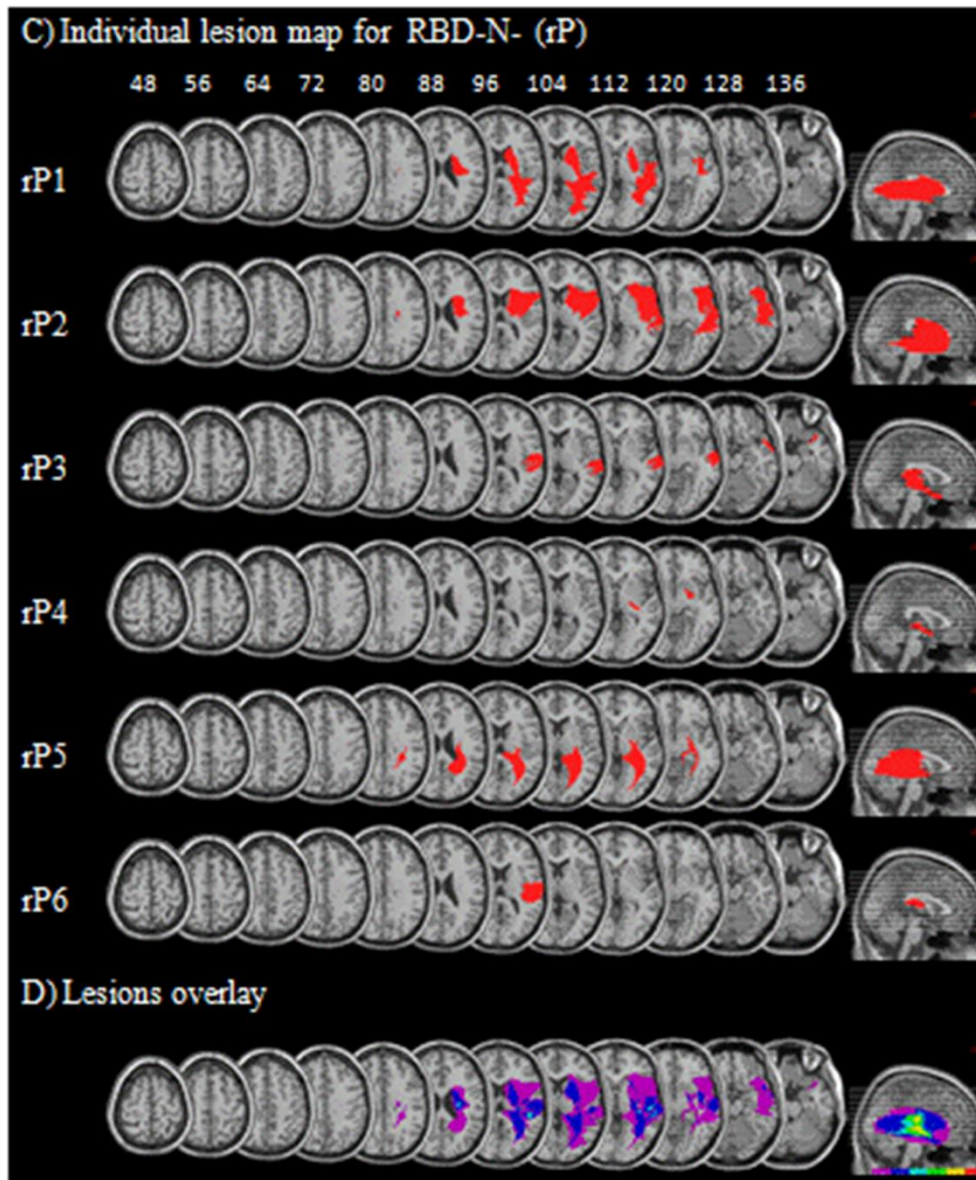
CT/MRI digitalized images. (A) individual lesions and (B) lesion overlay analysis of seven right brain damaged patients with neglect (RBD-N+) (nP); (C) individual lesions and (D) lesion overlay analysis of six right brain damaged patients without neglect (RBD-N-) (rP). Individual lesions are marked in red. In the lesion overlay, each patient's lesion is given in a distinct color with the region of maximum overlap indicated in red.
